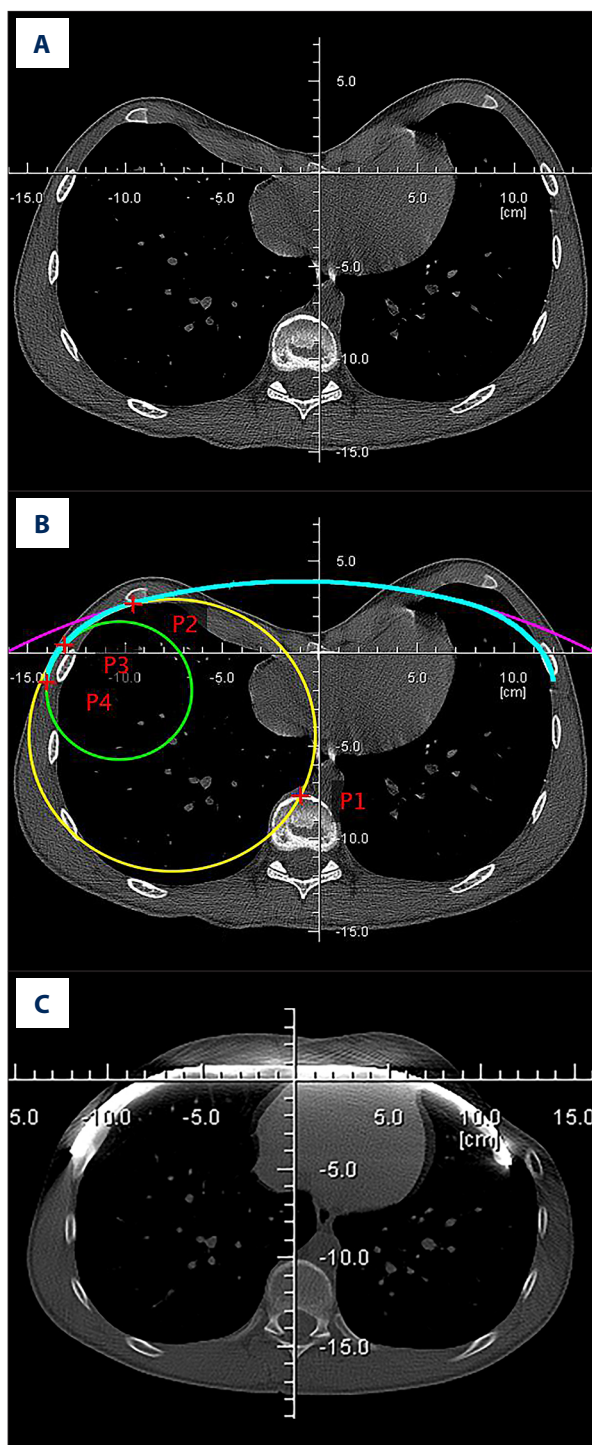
(A) Preoperative, (B) virtually planned, and (C) postoperative computed tomography scan of a patient. The patient was operated by the lead author. The first image shows the chest deformity. The second image displays the virtually edited shape and appropriate length of the bar. The third image shows the postoperative condition. The examination was conducted for another medical condition. *The software used for figure creation was Phyton.*
